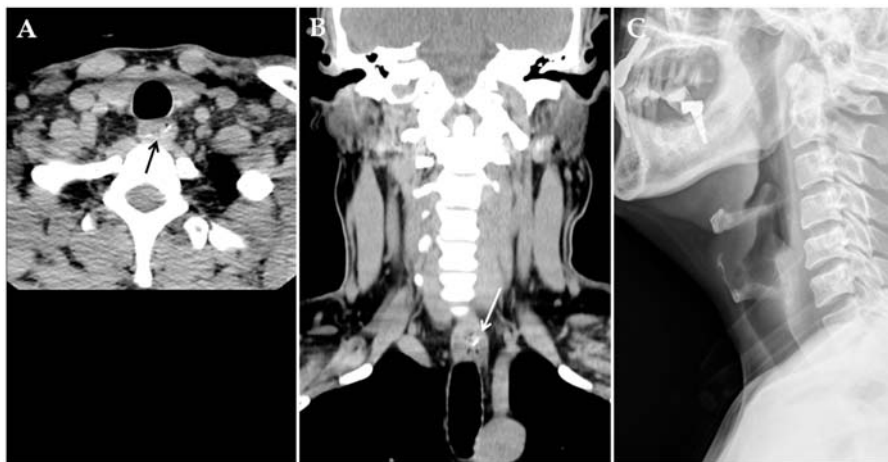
A 48-year-old man with odynophagia. Axial (A) and coronal (B) CT scans reveal a high density foreign body positioned transversely in the cervical esophagus (arrow). There is no remarkable finding on the lateral projection of cervical radiography (C). Flexible esophagoscopy confirmed the foreign body in the cervical esophagus.
